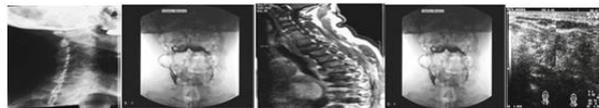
1 X-Ray axial CT MRI fluoroscopy ultrasound
